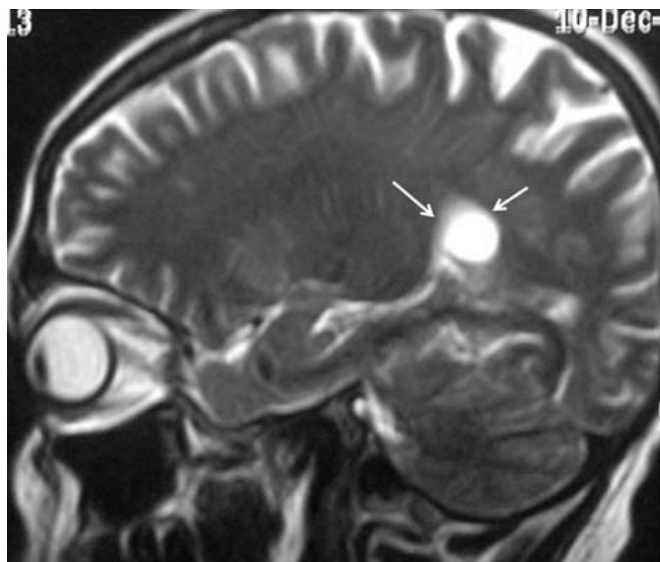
MRI of the brain showing a ring-enhancing lesion in the peritrigonal area with minimal perifocal oedema and ependymal enhancement (white arrows).
